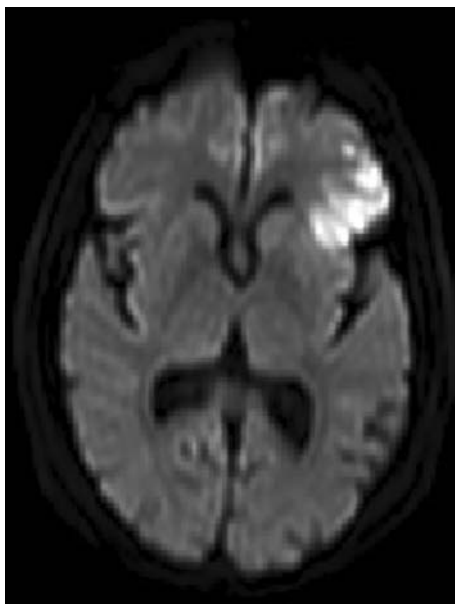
MRI scan from a patient with Broca's aphasia immediately after stroke. MRI images are displayed in the standard orientation used in radiology, with the left side of the brain on the right side of the image. This is a diffusion-weighted image, showing an acute, left frontal infarction.
